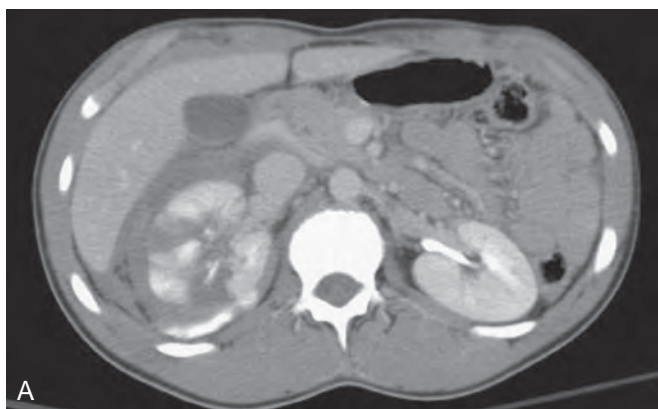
Acute and delayed images of grade 4 right renal injury. A and B, Acute computed tomography (CT) images of grade 4 renal trauma with perinephric hematoma, severe (>1 cm) fractures with devitalized renal segments, and urinary extravasation. C and D, Ten-minute delayed CT images revealing flow of contrast in ureter distal to injury, confirming patency of distal ureter. Patient was treated with observation only; no stent or drainage was necessary.
